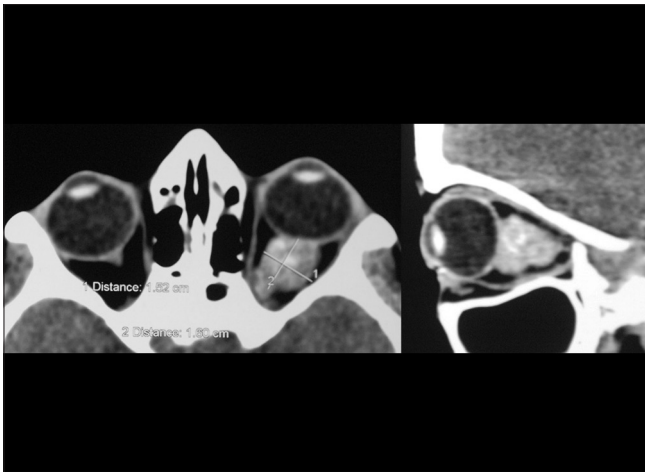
Hyperdense lesion with calcification involving retrobulbar, intraconal compartment and encircling the optic nerve in left orbit on axial and sagittal computed tomography scan
